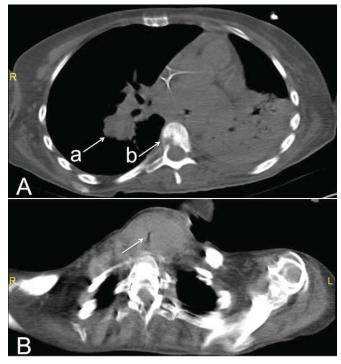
A) CT of the chest, showing a hilar mass (a) and metastatic bony lesion (b). Patient also has remnants of pneumonia on the left side. B) Enlarged thyroid closes the trachea above tracheostomy (arrow).
